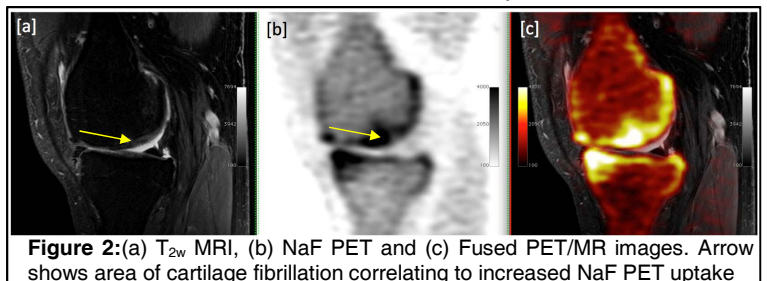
(a) T_{2w} MRI, (b) NaF PET and (c) Fused PET/MR images. Arrow shows area of cartilage fibrillation correlating to increased NaF PET uptake
